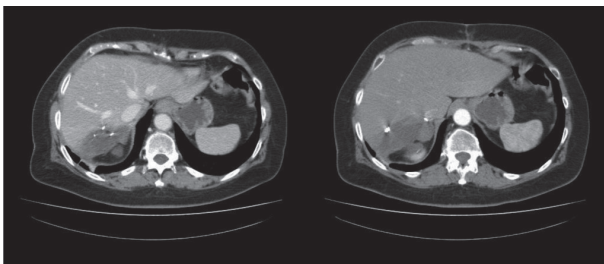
After a six-cycles-Folfox neoadjuvant regimen, these CT post-operative imaging shows common findings after surgical resection. The hepatic malignant lesion is conformed with the addition of “blue liver” as chemotherapeutic liver adverse reaction
